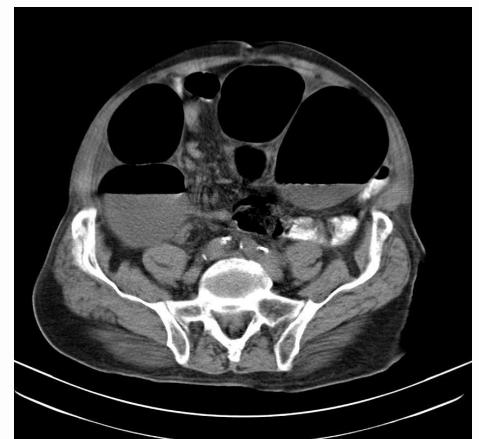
Axial image of CT abdomen and pelvis without contrast showing sigmoid volvulus. Creative Commons license: Case courtesy of Dr. Bruno Di Muzio, Radiopaedia.org, rID: 17788.
